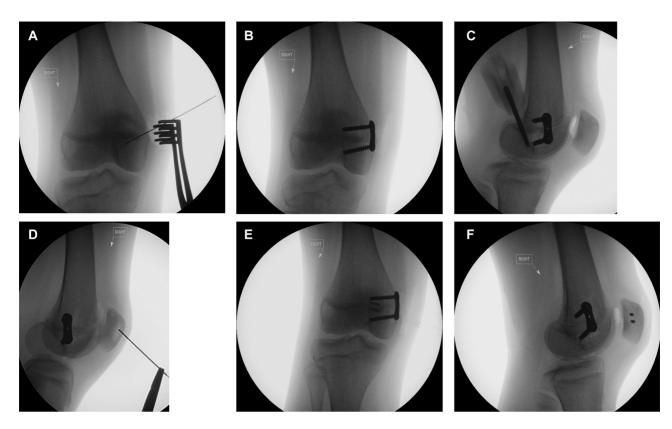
Intraoperative radiographs of distal medial femoral hemiepiphysiodesis and medial patellofemoral ligament (MPFL) reconstruction using gracilis allograft in a 13-year-old patient. (A) Identification of the physis via K-wire. (B) Medial 8-plate in situ. (C) Physis-sparing identification of the femoral MPFL insertion point. (D) Identification of the patellar graft insertion point. (E) Anteroposterior image after MPFL reconstruction and hemiepiphysiodesis. (F) Intraoperative lateral view.
